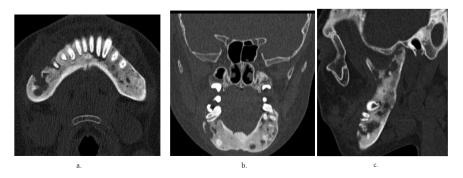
(case 3). 20-year-old male patient with fibrous dysplasia. (a) Axial, (b) coronal, and (c) sagittal maxillofacial computed tomography images showing diffuse infiltrative expansile ground glass areas extending towards the bilateral corpus and rami of the mandible, and involving small lytic areas and radiodense sclerotic areas.
